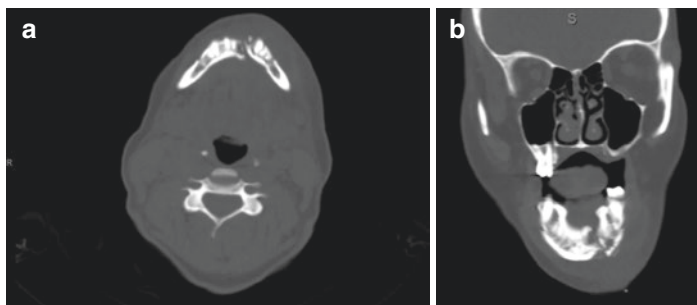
(a) Axial CT scan showing fracture of the mandible and adjacent osteolytic changes. (b) Coronal CT view showing fracture of the mandible and adjacent osteolytic changes
